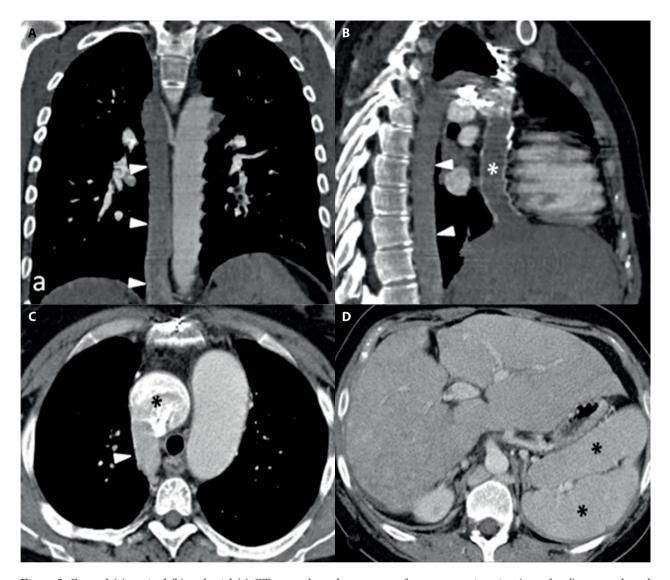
Coronal (a), sagittal (b) and axial (c) CT scans show the presence of azygous continuation (arrowhead) to an enlarged superior vein cava (* in c). Upper abdominal CT scan (d) depicts the presence of two spleens (*).
